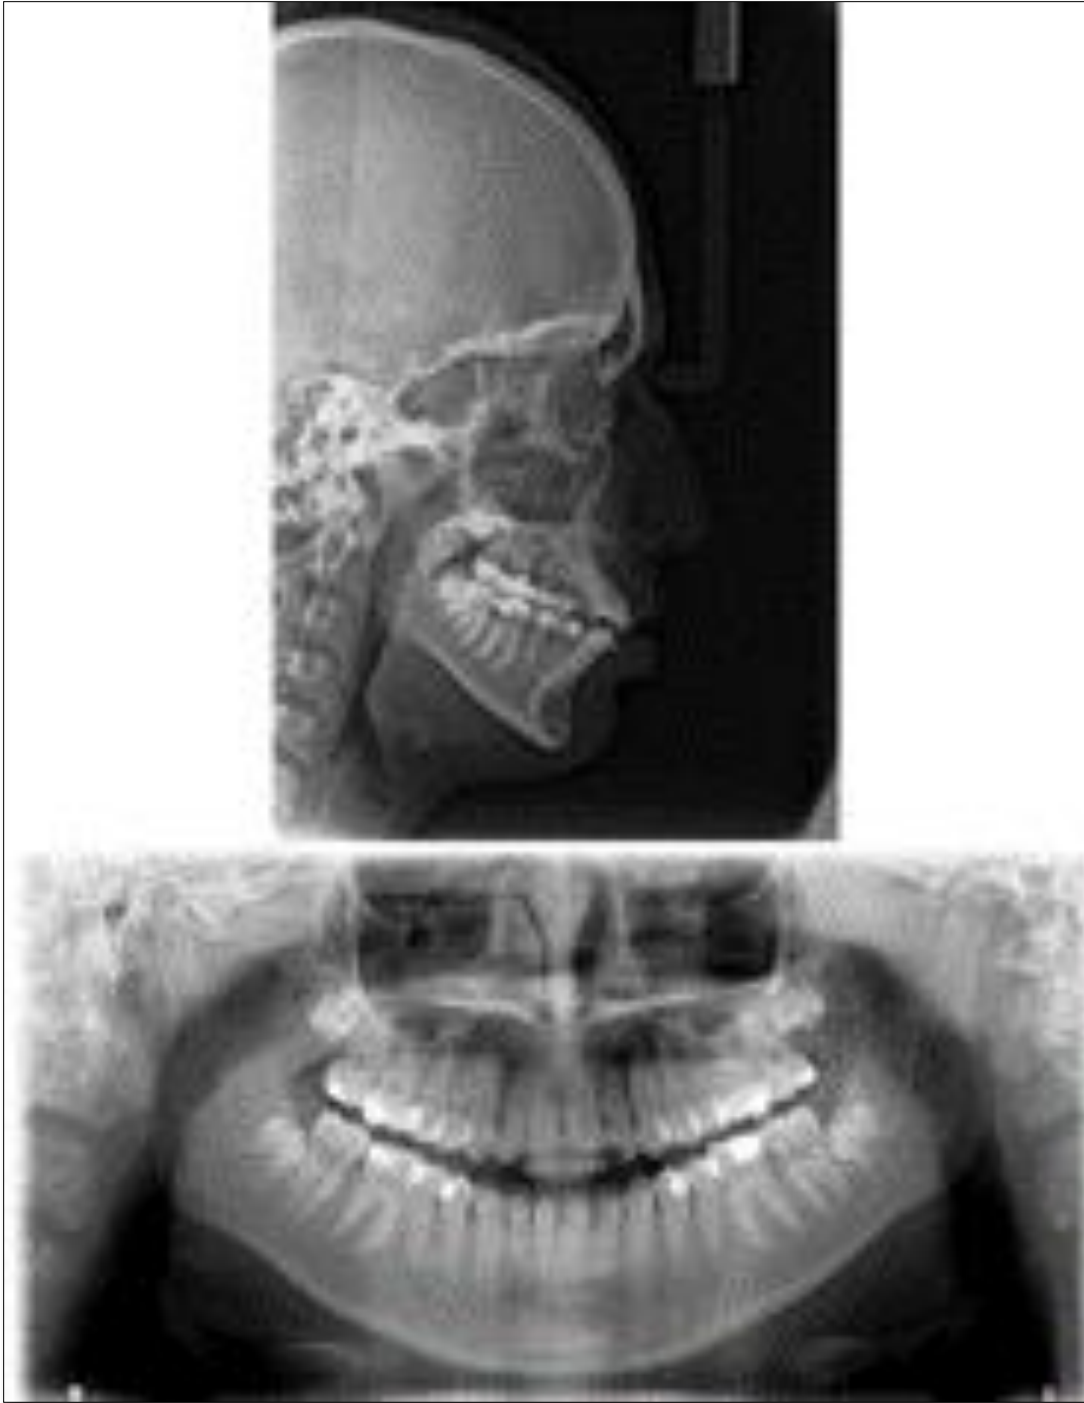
Mid treatment Radiographs.
